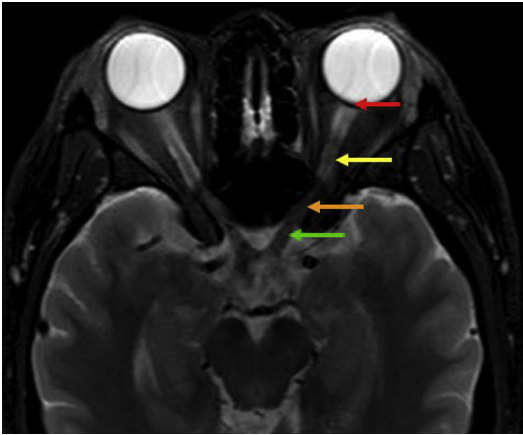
The 4 segments of optic nerves. Axial T2-weighted image shows intraocular (red arrow), intraorbital (yellow arrow), intracanalicular (orange arrow), and intracranial (green arrow) segments.
